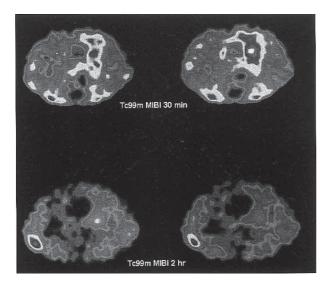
Tc-99m MIBI SPECT findings in patient 14. Early images demonstrate increased uptake in the left upper lung corresponding to tumor. But delayed images of Tc-99m MIBI show faint uptake in tumor area. Although his tumor partially regressed, (the patient was accepted as a good responder) he died at 11 months after this MIBI study.
